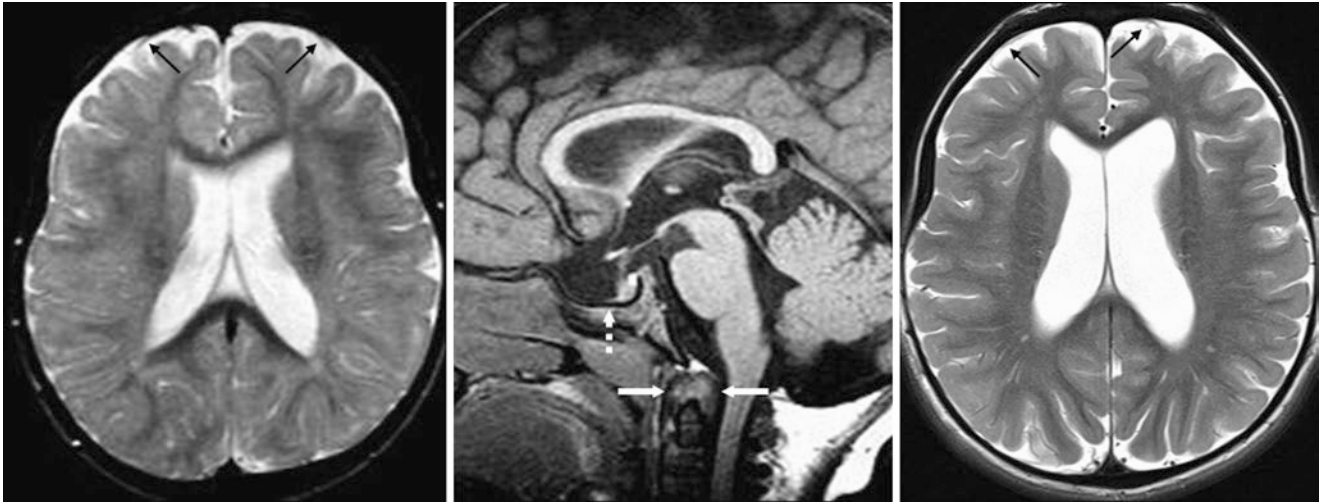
Comparison case of enlarged SASs in mucopolysaccharidosis. In a 19-month-old, a T2WI MRI (*left*) showed mildly prominent SASs of the frontal convexities, with cortical veins (*thin arrows*) traversing them. On sagittal T1WI (*middle*), there was a nearly J-shaped
